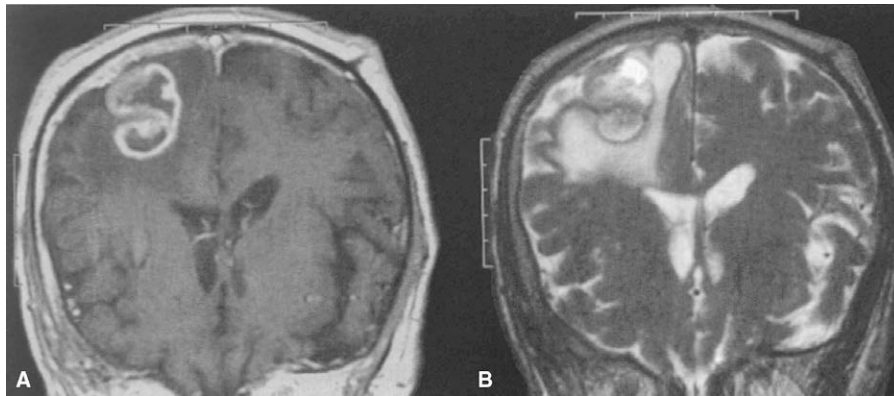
Typical glioblastoma MRI findings: T1-gadolinium contrast enhancement (left) and T2 hyperintensity (right).
